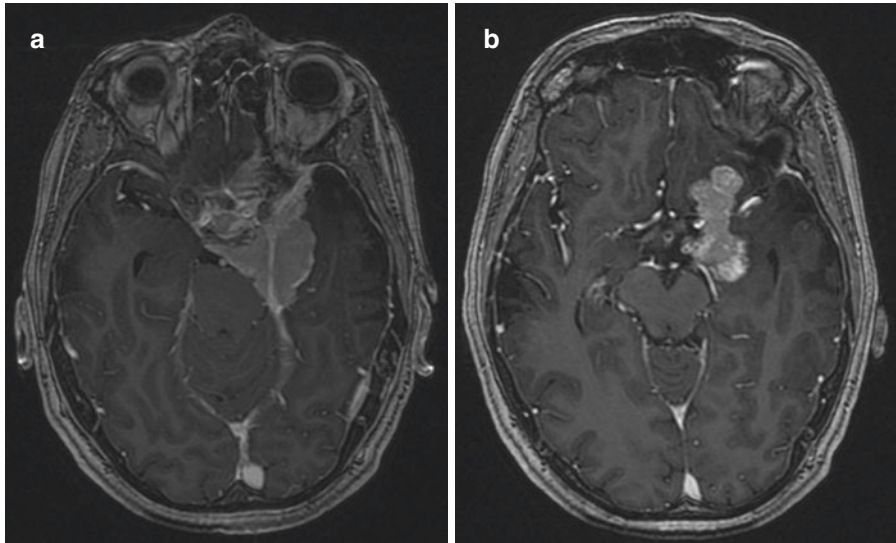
T1 MRI with contrast showing cavernous sinus meningioma
